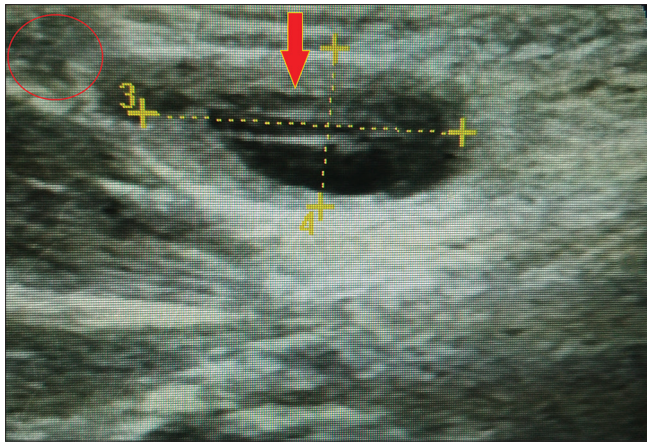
Longitudinal gray-scale ultrasonography showing small bowel loops (arrow) extending into the right inguinal region (circle). The mass was reducible and showed no signs of incarceration
